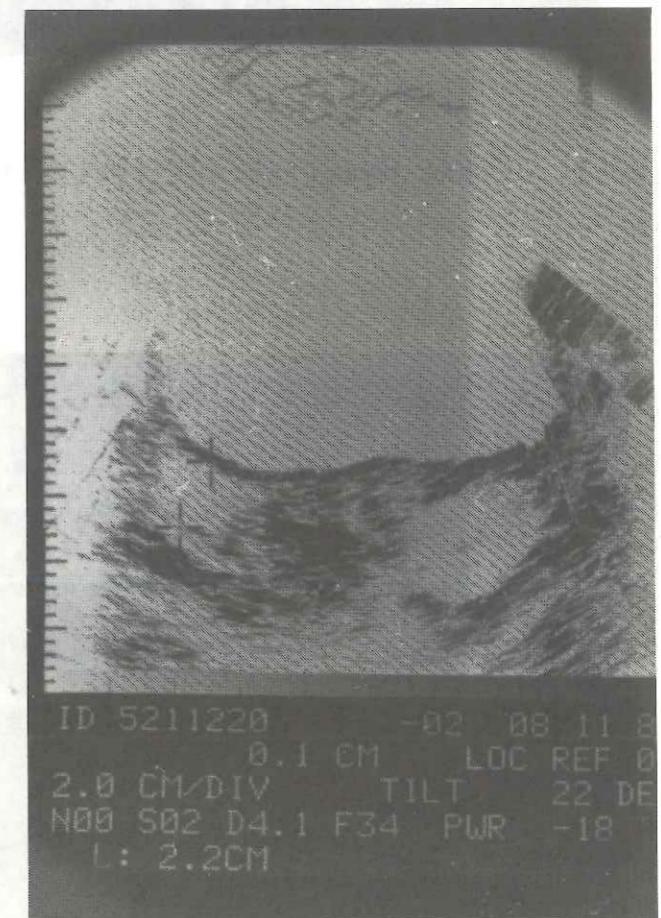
Normal ultrasonography : bilateral ovarian cysts.
